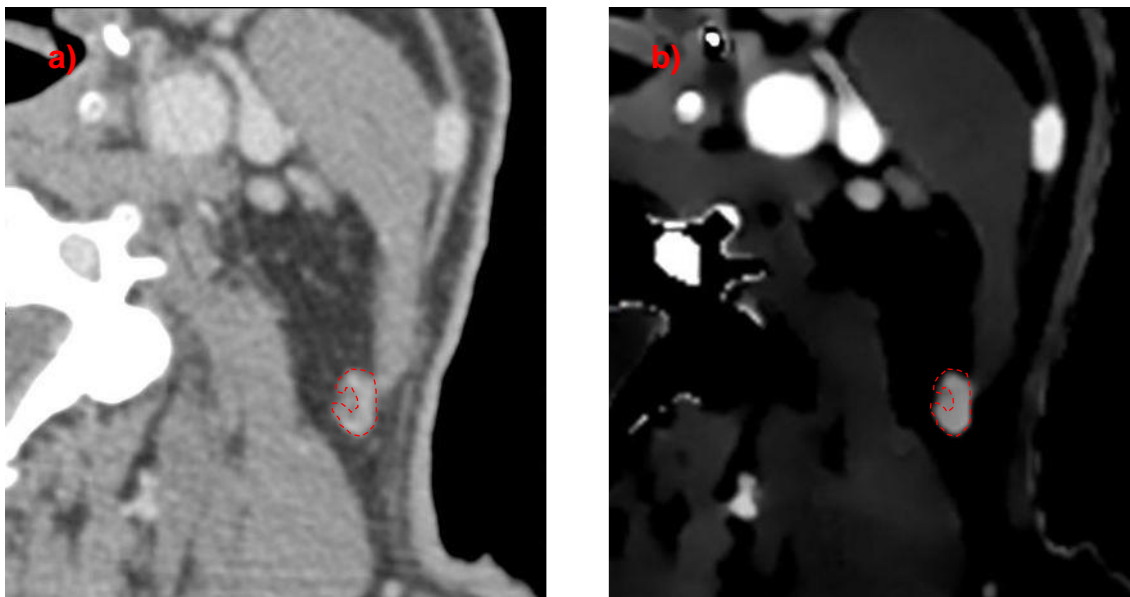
a) CT image of morphological unobtrusive lymph node subauricular on the left side (red dashed line) with HU b) with iodine concentration map. The bright area represents a high uptake of iodine congruent with the microanatomical dens capillary net in the peripheral part (Willard-Mack 2006; Bélisle and Sainte-Marie 1990).
